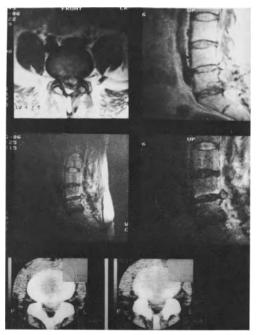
Disk recurrence at L4/5 is excellently visualized by MRI; CT (performed by Radiological Institute Dres. Kaesbach/Wierer, Kiel) failed to differentiate between scar and disk herniation
